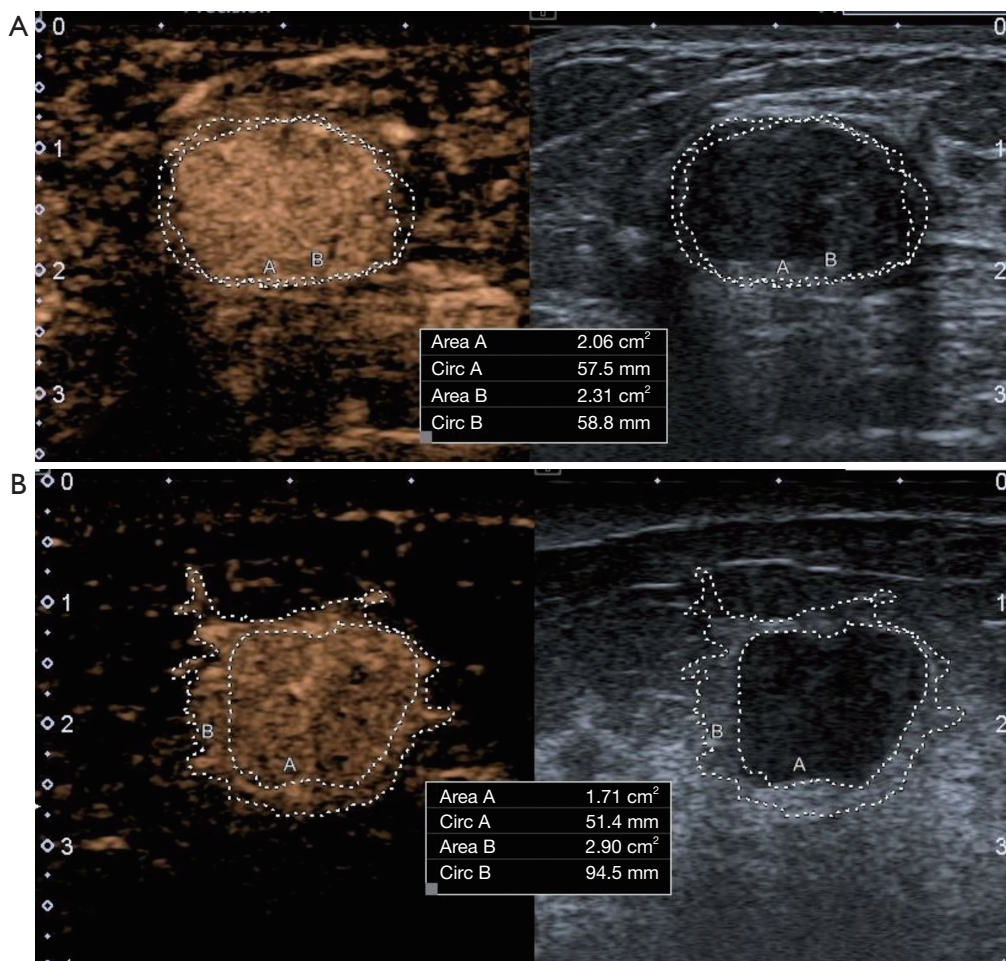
The area of lesion increment after enhancement. (A) In a 33-year-old female with FA, the area increment was not obvious after enhancement (compared with conventional ultrasound). (B) In a 71-year-old female, the area increment of the IDC was 1.19 cm² after enhancement. FA, fibroadenoma; IDC, invasive ductal carcinoma.
